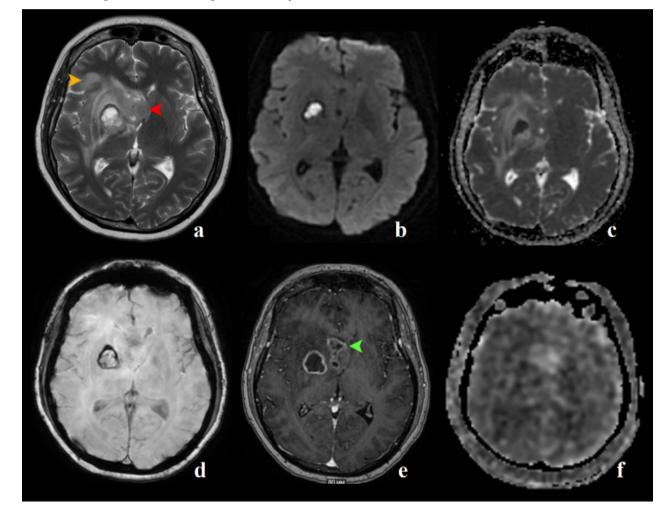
Patient B., 45 y.o., with multifocal glioblastoma, after «Stupp-protocol» (radiotherapy – total 60 Gy, 2 Gy per daily fraction over 6 weeks; temozolomide – during radiotherapy: 75 mg per square meter of body-surface area per day, 7 days per week; post-radiotherapy (adjuvant): 6 cycles consisting of 150–200 mg for 5 days during each 28-day cycle). On axial T2 images at the level of the basal ganglia (a), the tumor involves the putamen, globus pallidus, and predominantly infiltrates the head of the caudate body and the thickened right fornix (red arrow). In addition, the glioma invades the gray matter of the cortical plate of the frontal operculum (yellow pointer). In the area of the globus pallidus there is a small hematoma in the early subacute phase after hemorrhage, which has a high signal on T2 (a) and T1 (e) images and limits diffusion due to the viscosity of the blood clot, which is manifested by a high signal in DWI b = 1000 (b) and low signal on the ADC (c). The hematoma shows low signal in the periphery on SWI (d) due to hemosiderin, accumulating contrast agent in a closed ring pattern with walls of uniform thickness on post-contrast T1 image (e), due to a disrupted blood-brain barrier. The tumor-affected fornix on the right accumulates contrast in a similar manner but has a "corona effect" in the structure (green pointer), which is found in the necrotic cavities of gliomas, and shows an increase in signal on raw ASL perfusion data (f), characteristic of the most malignant component heterogeneous diffuse glioma.
